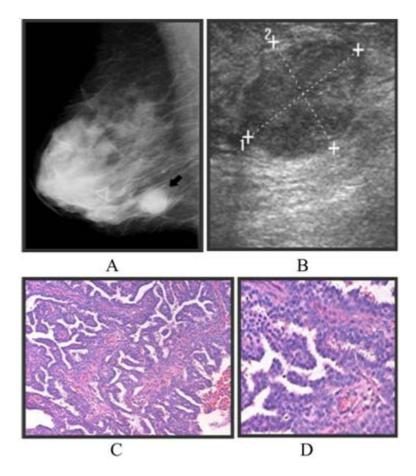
Atypical papillary lesion. A: Mediolateral oblique view of the right breast showing a slightly hyperdense mass with partially circumscribed, obscured margins (indicated by an arrow). B: Ultrasound image demonstrating a lobulated mixed solid cystic mass (indicated by arrows). C: High power field of pathology image indicating less than 30% of the lesion contains cytologic atypia (larger nucleus, basophilic cytoplasm, prominent nucleoli) and rare myoepithelial cells. D: Magnification image of the pathology.
